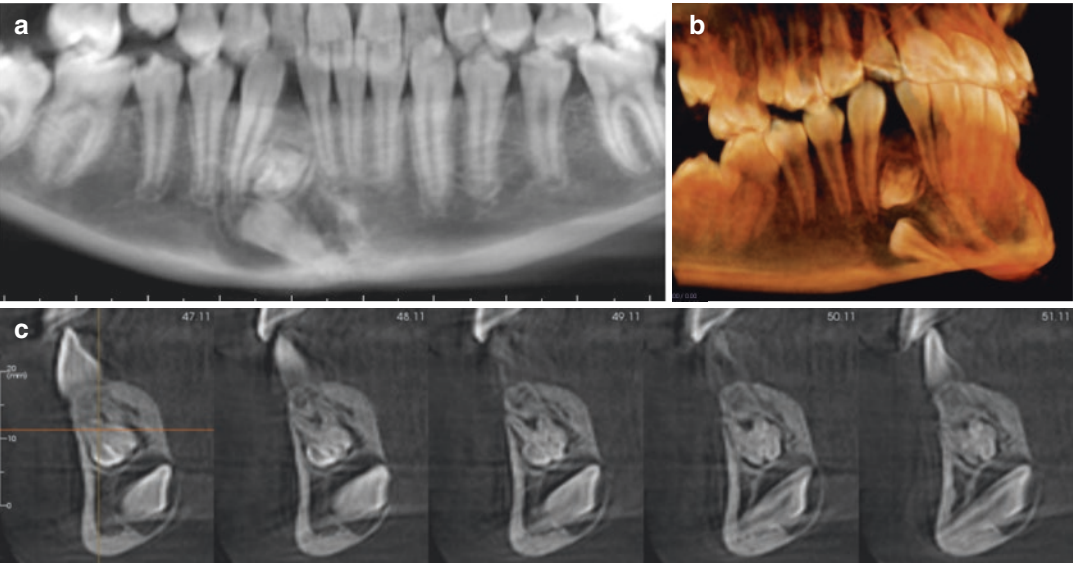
Sagittal (a), axial (b), and cross-sectional (c) CBCT images of the right mandibular posterior region in a child demonstrating bony replacement external resorption leading to ankylosis and subsequent submersion and impaction of the crown of a partially formed mandibular first molar
